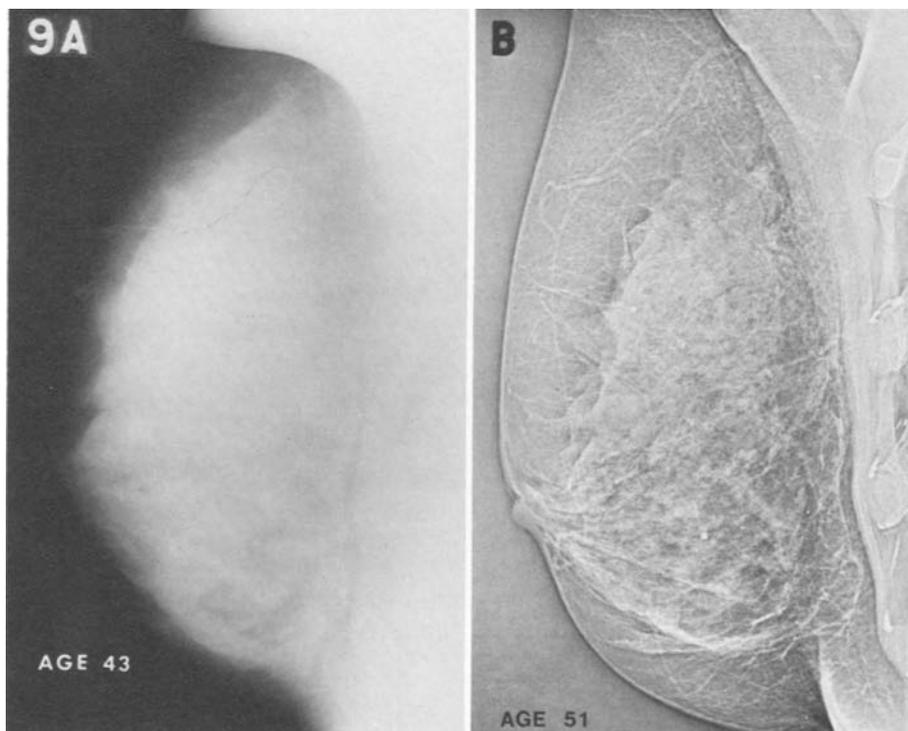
Radiographs taken 8 years apart reveal a persistent DY appearance. On the initial study at the age of 43, the coalescent areas of dysplasia are indicative of the DY classification. Although some duct pattern is beginning to develop in the subareolar area, at the age of 51 there are still coalescent areas of dysplasia and the classification should remain DY.
